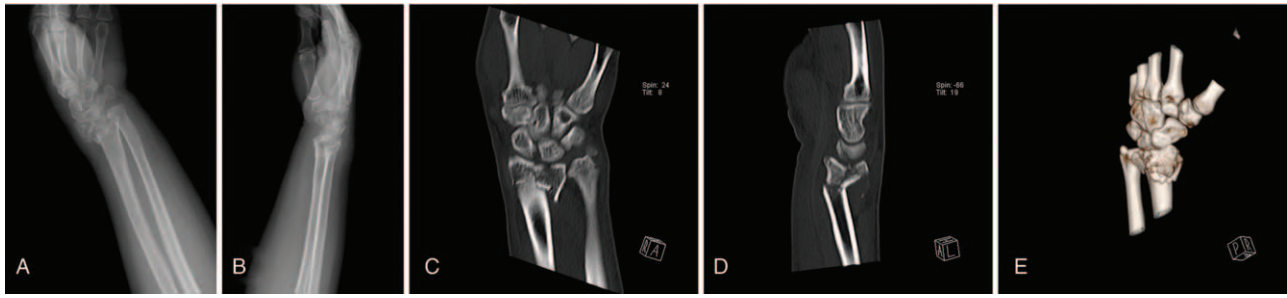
The preoperative X-ray (A, B), CT scanning (C, D) and reconstruction (E) showed a complete intra-articular fracture of the left distal radius involving the lunate facet, classified as AO type C fracture.
